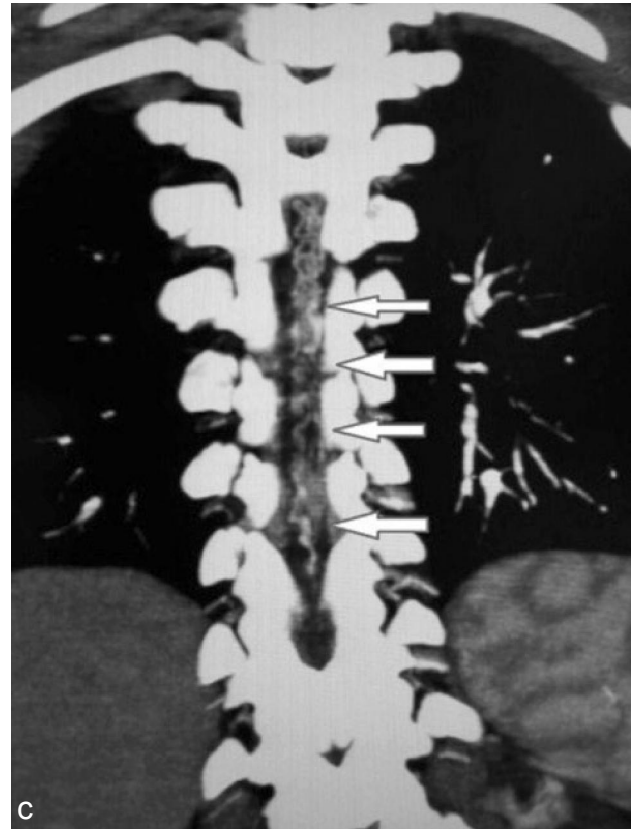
(a-b): Selected T2W and STIR sagittal MRI of the dorsal spine showing innumerable flow voids along dorsal aspect of spinalcord (white arrows) and hyperintensities with swollen cord (grey arrow), cutaneous lesions on anterior chest (asterix)
